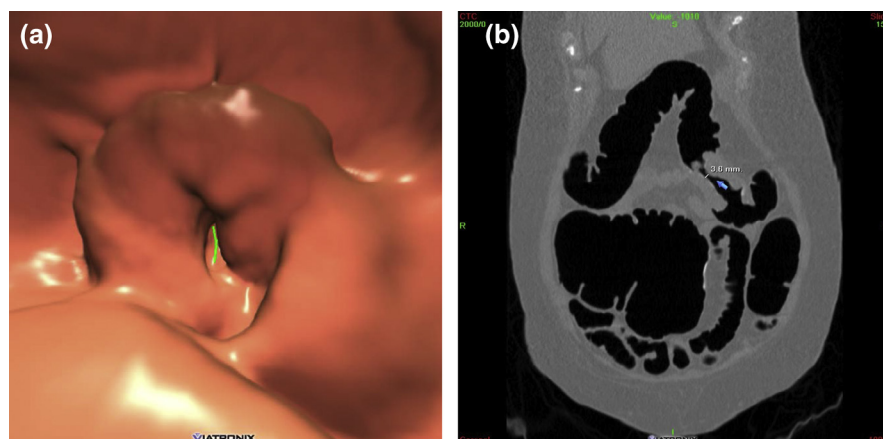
A 76-year-old woman with symptomatic GI bleed and anemia who underwent CTC examination following incomplete optical colonoscopy. Three-dimensional endoluminal CTC (a) and corresponding coronal CT (b) images show a 49-mm ring-like concentric mass in the transverse colon circumferentially involving the colon wall; the characteristic features of an annular cancer. CTC, computed tomographic colonography; CT, computed tomography; GI, gastrointestinal.
